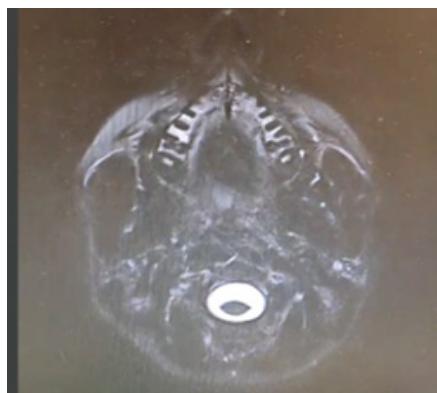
Sialo-MRI shows Stensen's ducts as a tubular hyperintense (white) structures. The presence of parenchymal, ductal anomalies or compression is excluded.
